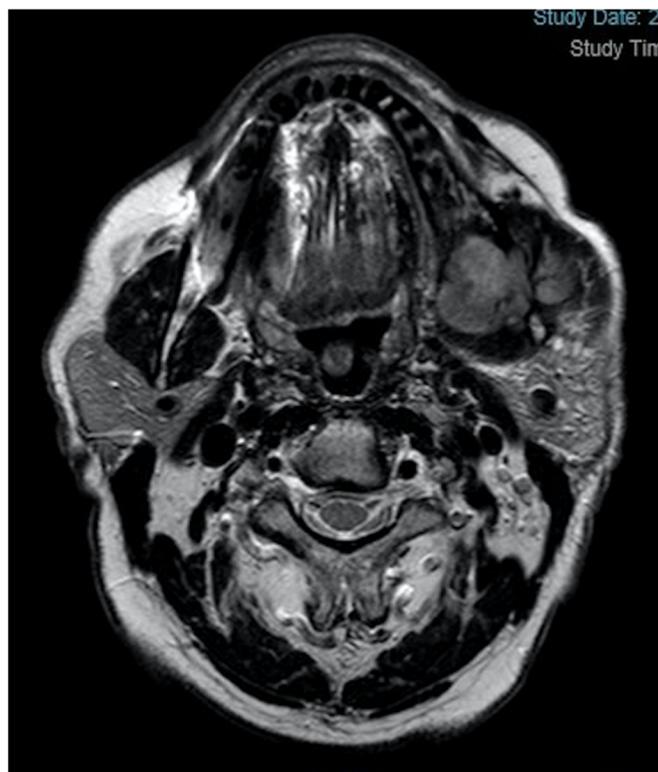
T1 time MRI in axial section, at 6 years, through the mandible, showing the expansive process in relation to the ascending branch of the mandible. (T1 time MRI in axial section, at 6 years, through the mandible, showing the expansive process in relation to the ascending branch of the mandible.)
